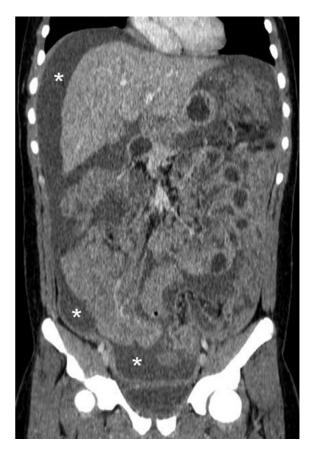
Coronal reformatted multidetector-row CT image of a patient with abdominal lymphoma showing multiple soft-tissue masses encasing mesenteric vessels associated with ascites (*asterisks*)
